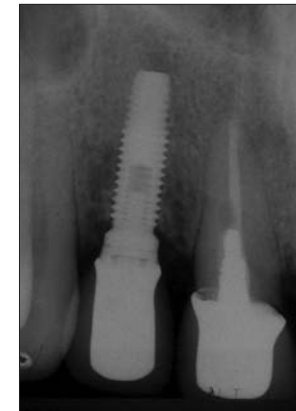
Radiograph after placement of final restorations.
